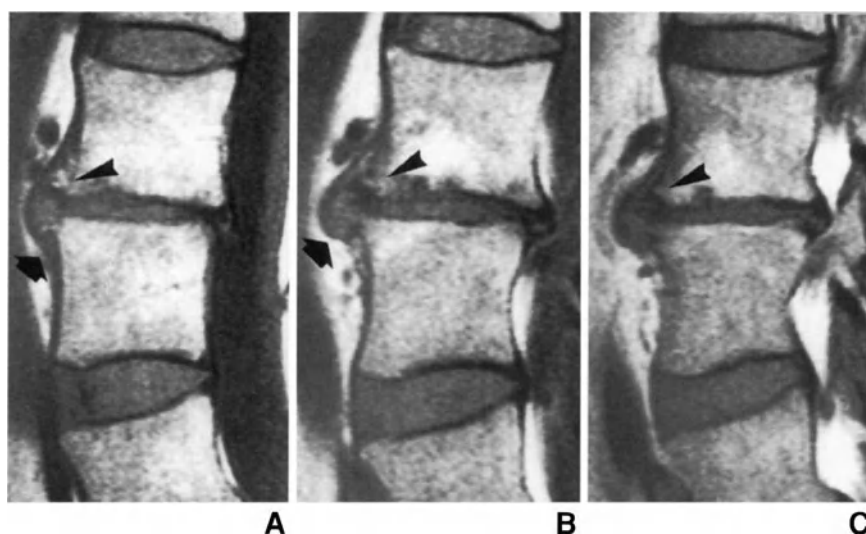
Sagittal T1-weighted MR images [(A) paramedian; (B) and (C) lateral] of the lumbar spine. The L4-L5 disc is markedly decreased in height. At this level, the anterior longitudinal ligament and periosteum appear to be detached from the vertebral bodies by a portion of disc tissue displaced ventrally (arrows). At the level of the caudal rim of the proximal vertebral body, subperiosteal reactive bone tissue and, in the lateral sections, a short osteophyte (arrowhead) can be seen.
